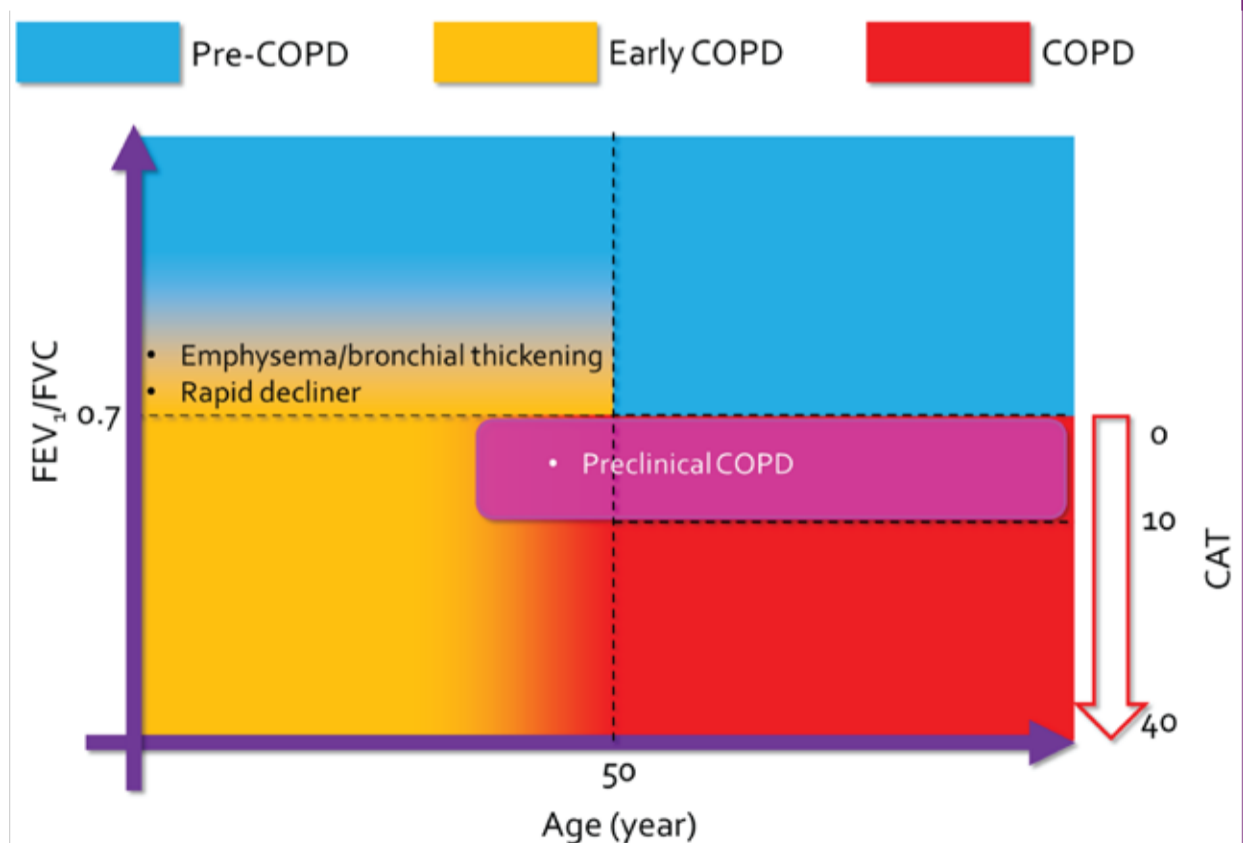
Definition of early COPD, pre-COPD and overt COPD. (From: Choi JY, et al. J Clin Med. 2020). In 2020, Martinez et al proposed a definition of early COPD in which diagnosis is made in patients <50 years of age with a smoking history ≥ 10 pack-years and fulfilling one or more of the following: FEV₁/forced vital capacity (FVC) below the lower normal limit; compatible computed tomography (CT) abnormalities, such as visual emphysema, air trapping, or bronchial thickening; evidence of accelerated FEV₁ decline (≥ 60 mL/year). This definition was established based on operational and practical considerations assuming that patients at an early age may not have developed significant COPD.²⁰
